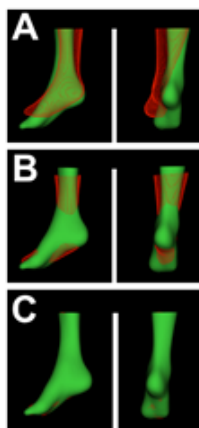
Serial registration of CT images of the lower extremities to correct for movement or change in position of limb between pre- and post-treatment study visits. Image registration was performed using points from outer skin surfaces. Shown are rendered surfaces from two separate study visits (red = visit 1; green = visit 2) at the (A) starting position before registration, (B) after global rigid alignment, and (C) after non-rigid registration.
